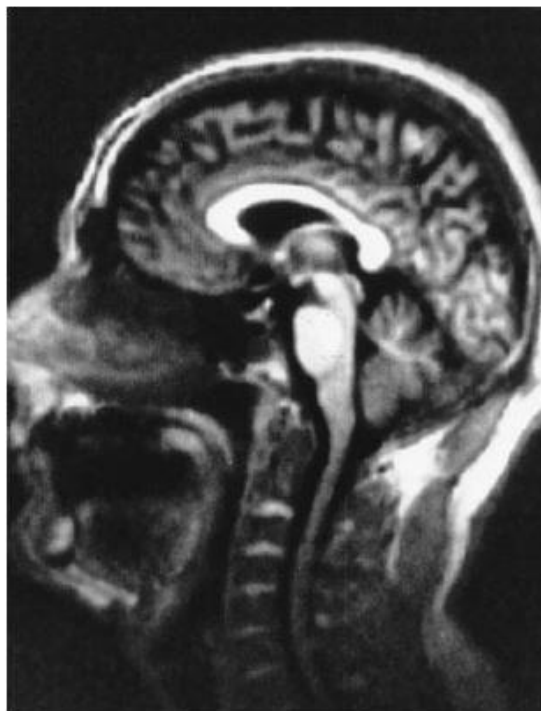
Sagittal anatomy IR scan using Spin-warp (1982). There is high contrast between white matter which is white, and gray matter which is grey. The sagittal plane could not be directly imaged with CT at this time.
